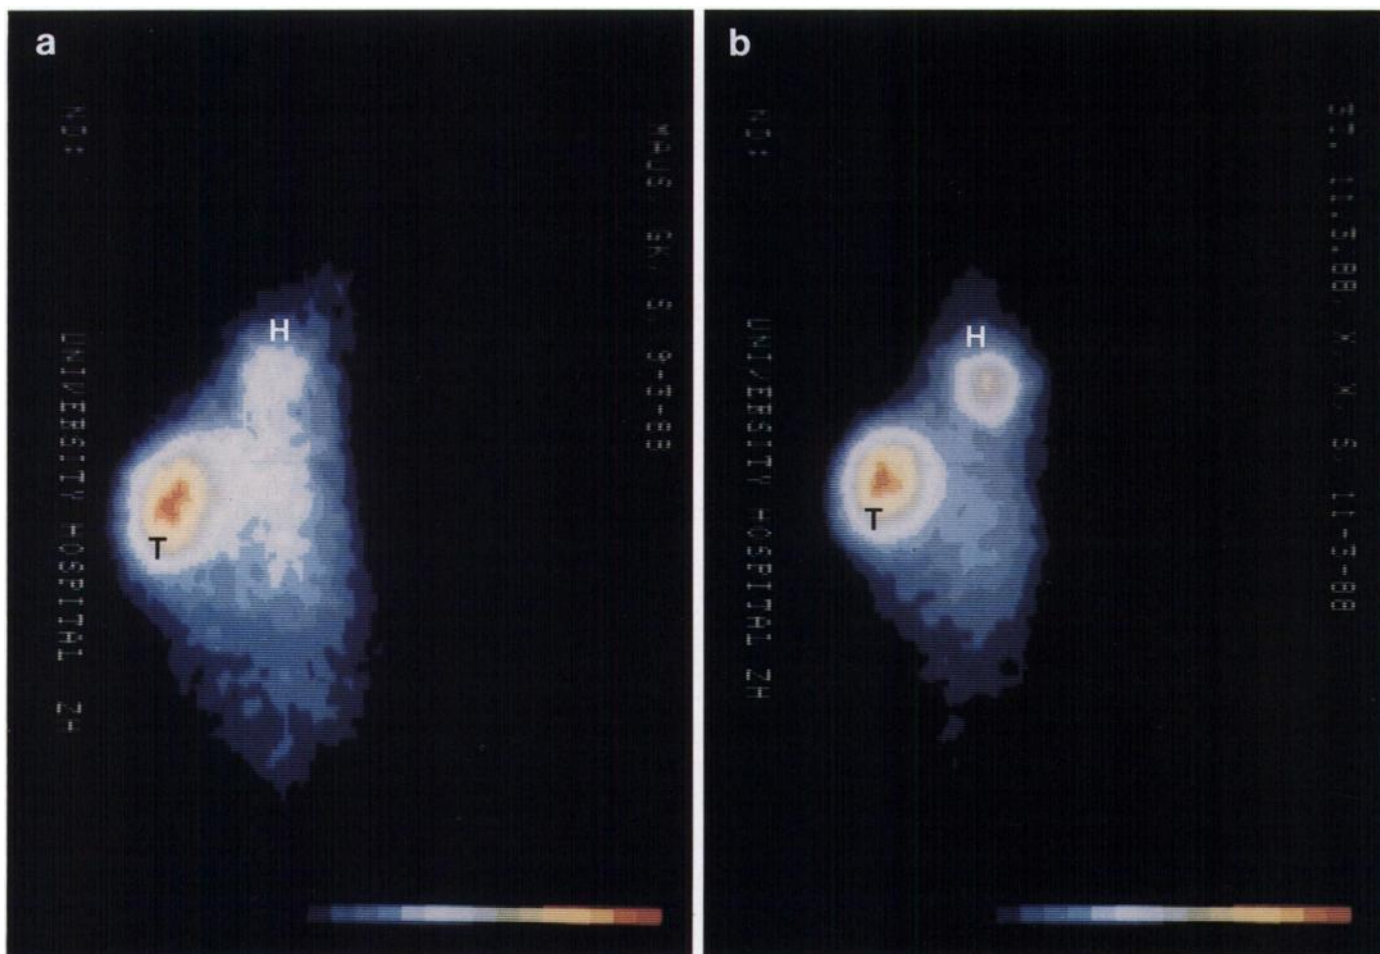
External gamma scintigraphy following i.v. injection of 100 μ Ci 131 I labeled SWA11. a, 2 days postinjection; b, 4 days postinjection. The head (*H*) and tumor (*T*) are indicated. No background subtraction or thyroid blocking was used.
